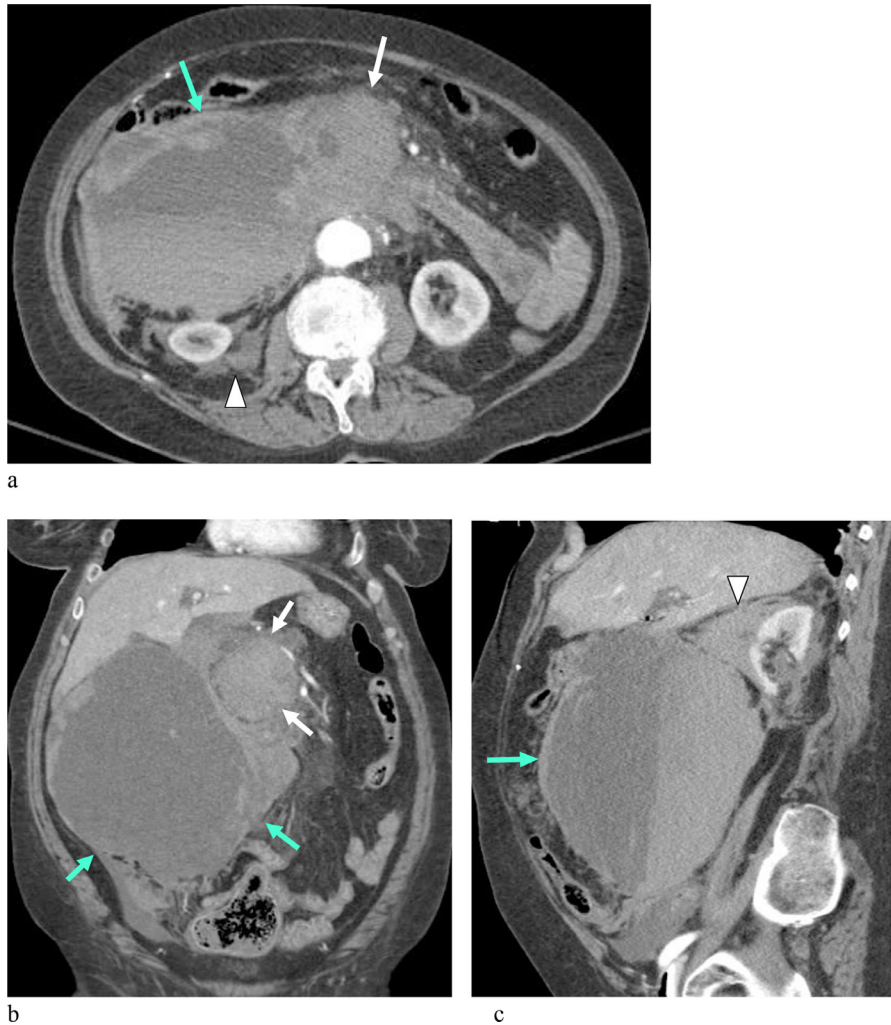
Axial (a), coronal (b), and sagittal (c) images from a contrast enhanced CT angiogram of the abdomen obtained after the patient became hemodynamically unstable demonstrates a large intraperitoneal (green arrows) and extraperitoneal hemorrhage (white arrowheads) extending outside of the previously visualized pancreatic pseudocyst (white arrows).
